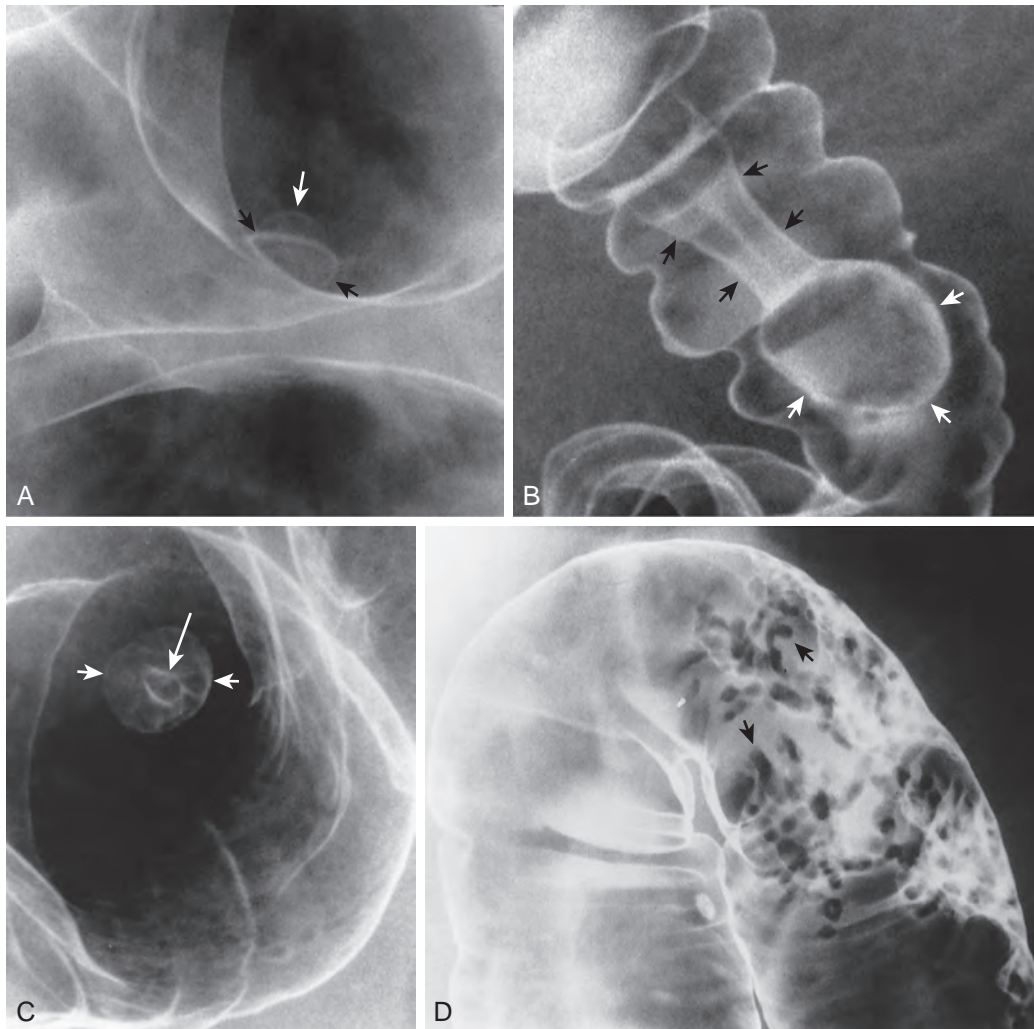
Polyp. A. Bowler hat polyp. Barium may be trapped between the edge of the polyp and intestinal lumen as the polyp is pulled against the adjacent wall by its stalk. If the surface and edge of the polyp are at the proper radiographic angle, the polyp appears similar to an English bowler hat. The ring (black arrows) of the polyp is the junction of the polyp and mucosal surface. The dome (white arrow) of the polyp points toward the longitudinal axis of the lumen. B. Pedunculated polyp. When a pedunculated polyp is seen in profile, the pedicle of the polyp appears as parallel barium-etched lines (black arrows) or as a tubular radiolucency in the barium pool. The head of the polyp (white arrows) is seen as a round or ovoid filling defect in the barium pool or is etched in white. C. Mexican hat polyp. If a pedunculated polyp is seen en face, the pedicle appears as a ring shadow (long arrow) central to the larger ring shadow of the head of the polyp (short arrows). These concentric ring shadows have been termed the *sombrero* or *Mexican hat* sign. D. Filiform polyp. A filiform polyp is a tubular or branched polyp, often with a clubbed head. Filiform polyps imply that there has been prior inflammatory disease involving the mucosal surface of the bowel. When residual inflamed, hyperplastic, or reparative tissue protrudes into the lumen, the resulting projections appear filiform. In this patient with quiescent Crohn's disease, numerous filiform polyps (arrows) are seen in the splenic flexure of the colon. (A from Miller WT, Levine MS, Rubesin SE, et al: Bowler-hat sign: A simple principle for differentiating polyps from diverticula. *Radiology* 173:615–617, 1989.)
